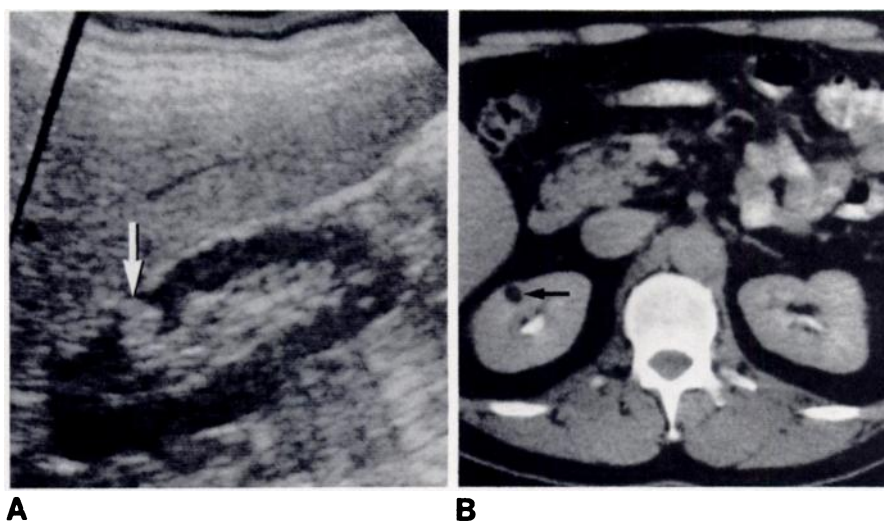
46-year-old man with symptoms of gallbladder disease. A, Sagittal sonogram of right kidney. Echogenic 1.3 cm lesion (arrow) within renal parenchyma. B, Contrast-enhanced CT scan confirms presence of fat-containing mass (arrow).
